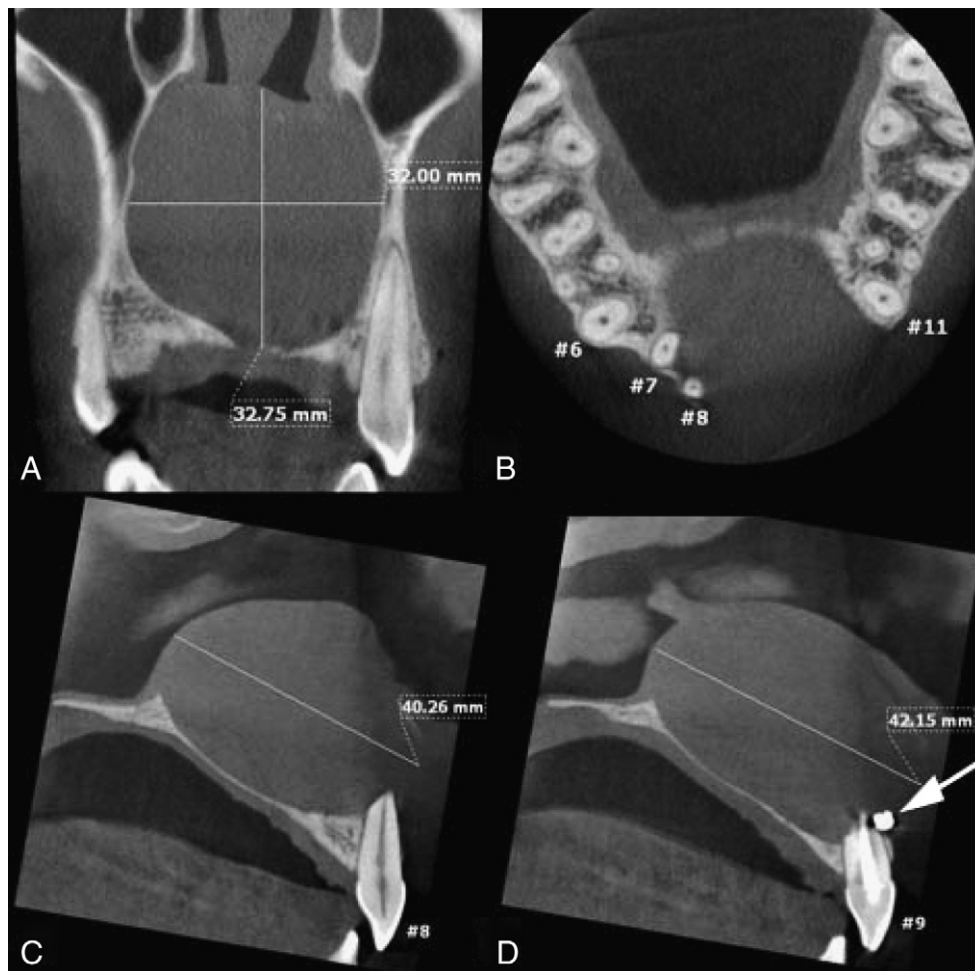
CBCT images of the anterior maxilla: (A) the coronal plane showed that the radiolucency was expanding into the nasal cavity up to the inferior concha with resorption of the bone. (B) The horizontal plane revealed the buccal cortical perforation. (C and D) In the sagittal planes, the resorption of the roots of teeth #8 and #9 and the overfilled endodontic material (*arrow*) were visible (orofacial cyst dimensions in millimeters).
